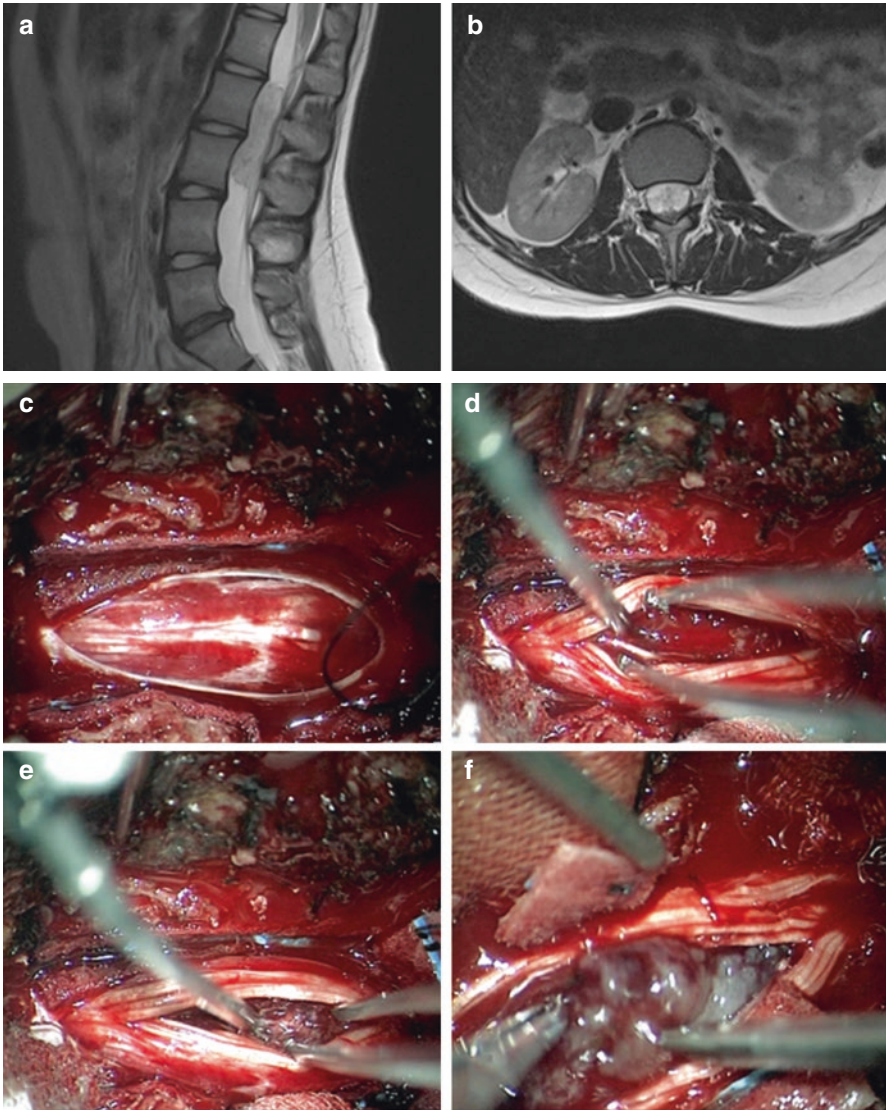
Sagittal T2-weighted post contrast (a) and axial T2-weighted (b) MRIs of an intradural-extradural conus ependymoma. Dural opening (c) exposing the filum terminale and conus medullaris. Intraoperative view of the tumor at the level of the conus medullaris (d) and filum terminale (e). Removal of the tumor (f), which is highly adhesive to the rootlets and vasculature
